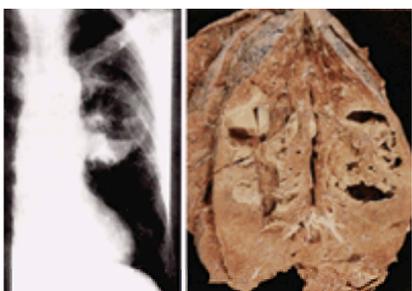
Cavitory air-space consolidation initially thought to represent necrotizing bacterial pneumonia (radiographic findings and autopsy material).
